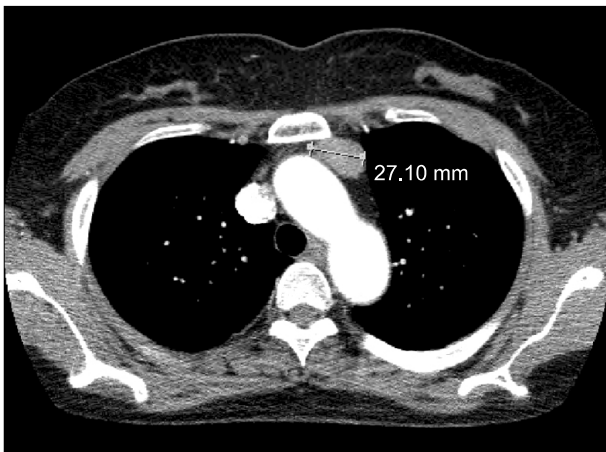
The computed tomography image showing an anterior mediastinal mass (arrow mark) having a diameter of 27 mm.
